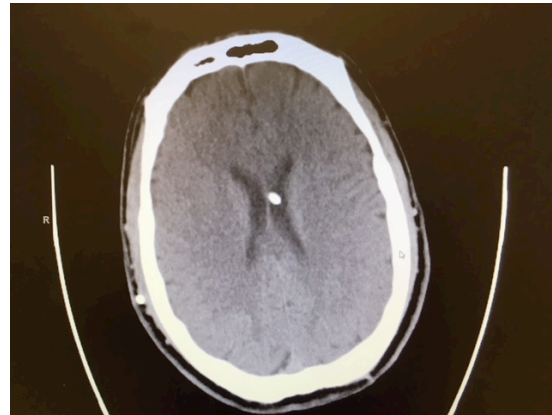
Figure above: A VP shunt shown on CT
